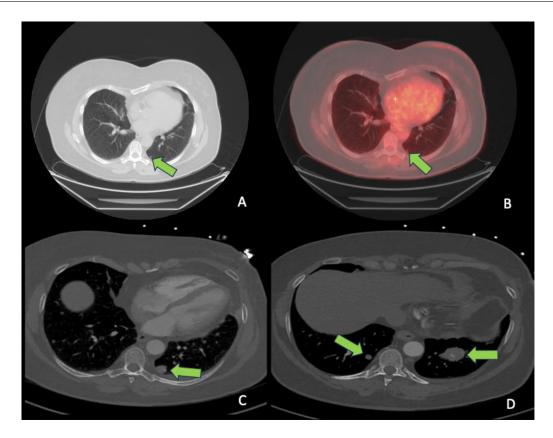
Pulmonary findings on initial staging PET/CT and subsequent CT chest after mastectomy. Axial images from initial staging PET/CT (A, B) demonstrating a subcentimeter pulmonary nodule (arrow). Axial images from subsequent CT chest with contrast 5 months after mastectomy (C, D) demonstrating multiple large pulmonary nodules (arrows) with central and peripheral foci of calcification.
